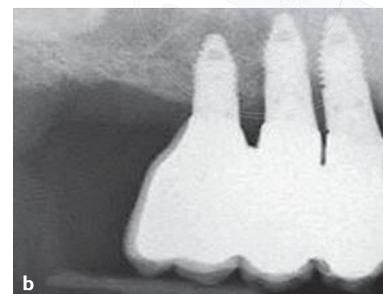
Periapical radiographs taken at 5 years after loading of representative sides randomised to 6-mm-long implants in (a) the mandibles and (b) the maxillae.
